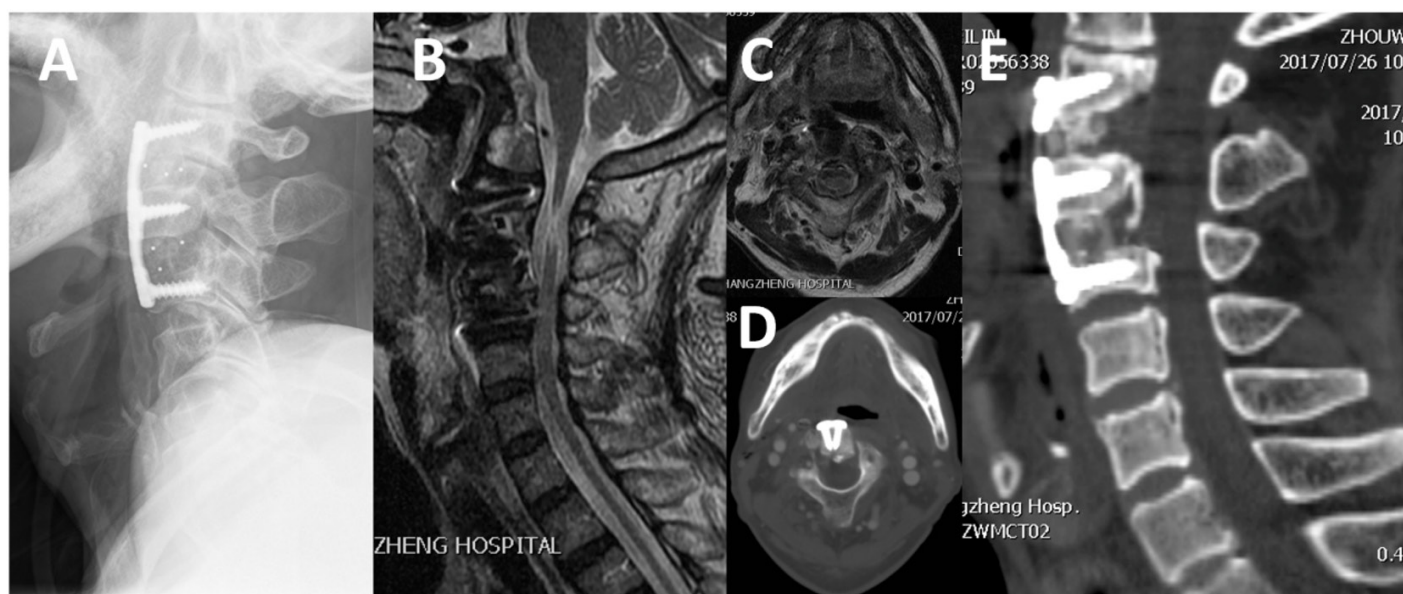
Post-ACAF images. (A) Postoperative x-ray showing good internal fixation and realignment; (B) MRI revealing increased spinal canal diameter at C3-C4 and resolution of spinal compression; (C) Transverse image at the C2/3 level showing absence of spinal compression; (D) Transverse image at the C3 level showing a sagittal canal diameter of 14.9 mm; (E) Sagittal CT reconstruction confirming stable internal fixation and appropriate bone graft placement. The sagittal canal diameters at C2, C3, and C4 were 13.0 mm, 15.0 mm and 8.2 mm, respectively. ACAF, anterior controllable antedisplacement and fusion.
